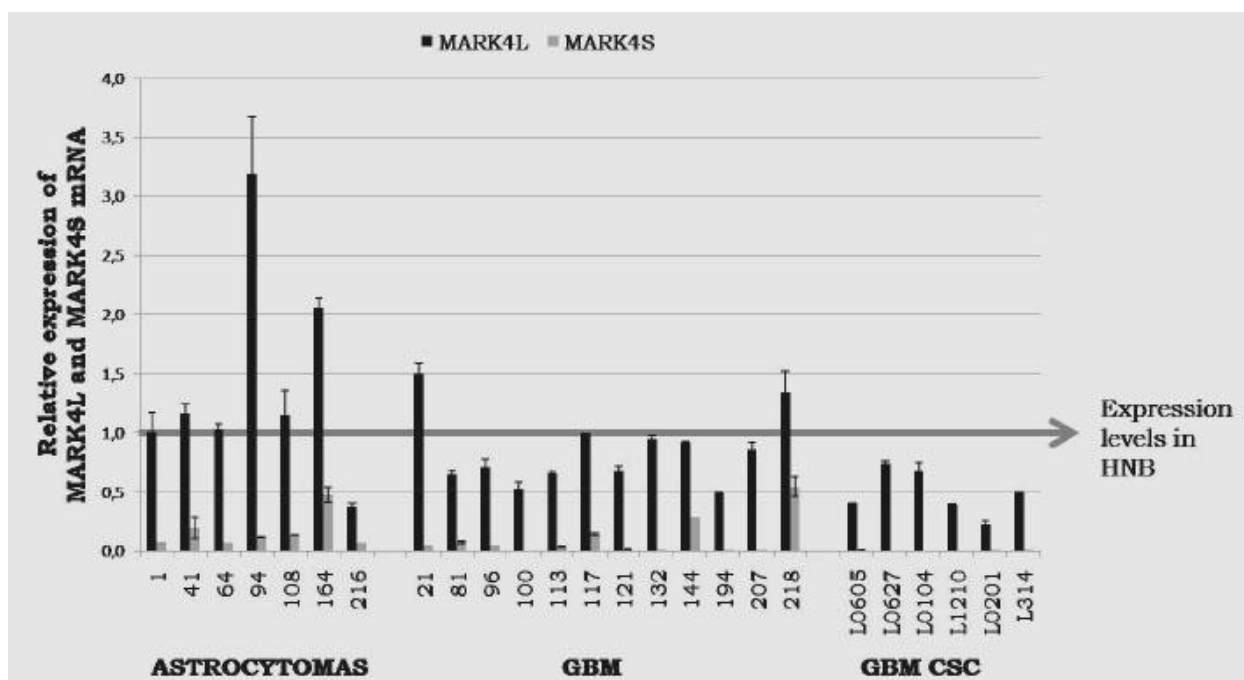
relative expression ($2^{-\Delta\Delta CT}$) of MARK4L and MARK4S in astrocytomas, glioblastomas (GBM) and GBM-derived cancer stem cells (GBM CSC) by Real-time quantitative PCR. Expression levels are referred to Human Normal Brain (HNB), chosen as reference and whose values were set as 1. Expression data are shown as mean \pm standard error.
